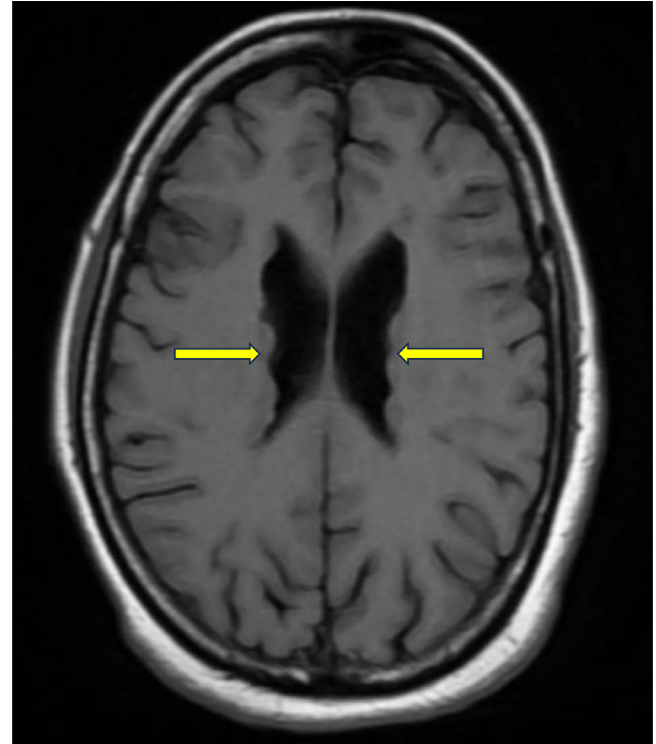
Axial MRI T2WI: multiple nodular periventricular subependymal altered signal intensity lesions diffusely along the body of both lateral ventricles following gray matter signal intensity (yellow arrows).
